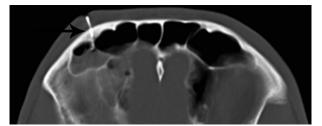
Noncontrast computed tomography scan of the head bone window shows the fractured portion of the TASER dart embedded in the right frontal sinus (arrow). Blood is also seen layering in the right frontal sinus.
